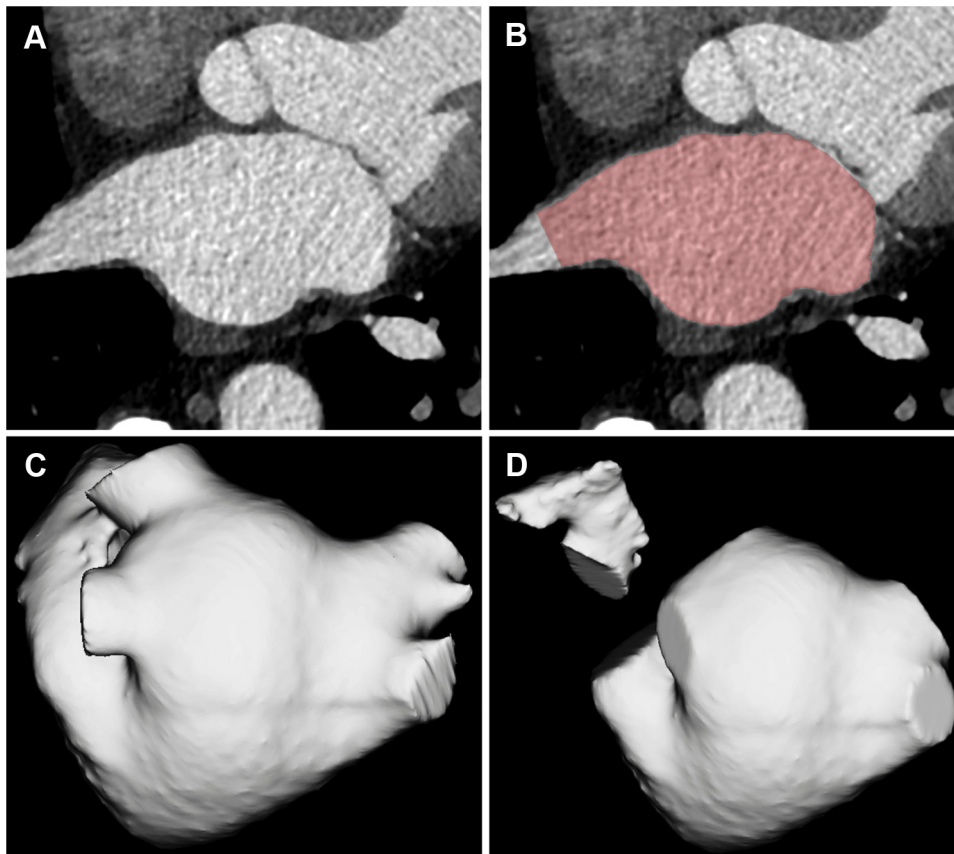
Image segmentation. Arterial-enhanced computed tomography images (A) were segmented using 3-dimensional region growing segmentation (B) to derive a mesh of the left atrial (LA) geometry comprising the left atrial appendage (LAA) and the first centimeter of pulmonary veins (PVs) (C), used to compute the shape score. Then, the PVs and the left appendage were cut at their ostia (D) to produce 1 mesh of the LA body, used to compute the LA volume, anteroposterior diameter, sphericity, and vertical asymmetry, and 1 mesh of the LAA, used to compute the LAA volume.
